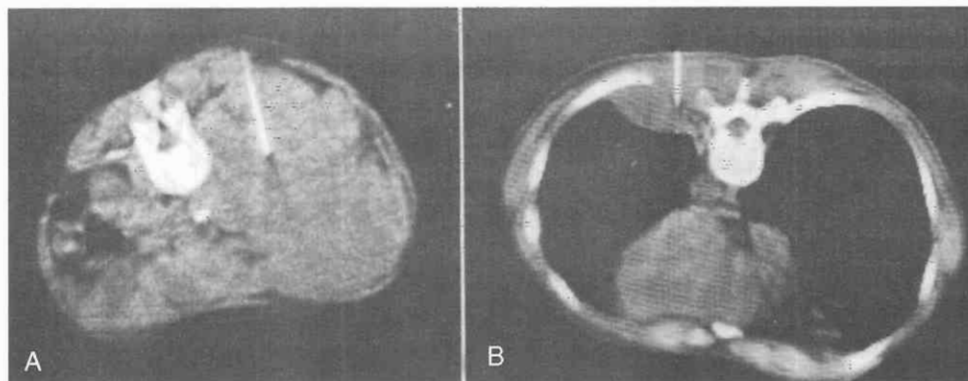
A, First CT guided biopsy was of a retroperitoneal mass (by the author). Even though the results of this biopsy were negative, the merits of CT guidance were obvious. B, First CT-guided procedure of the lung in 1975 (by the author).
